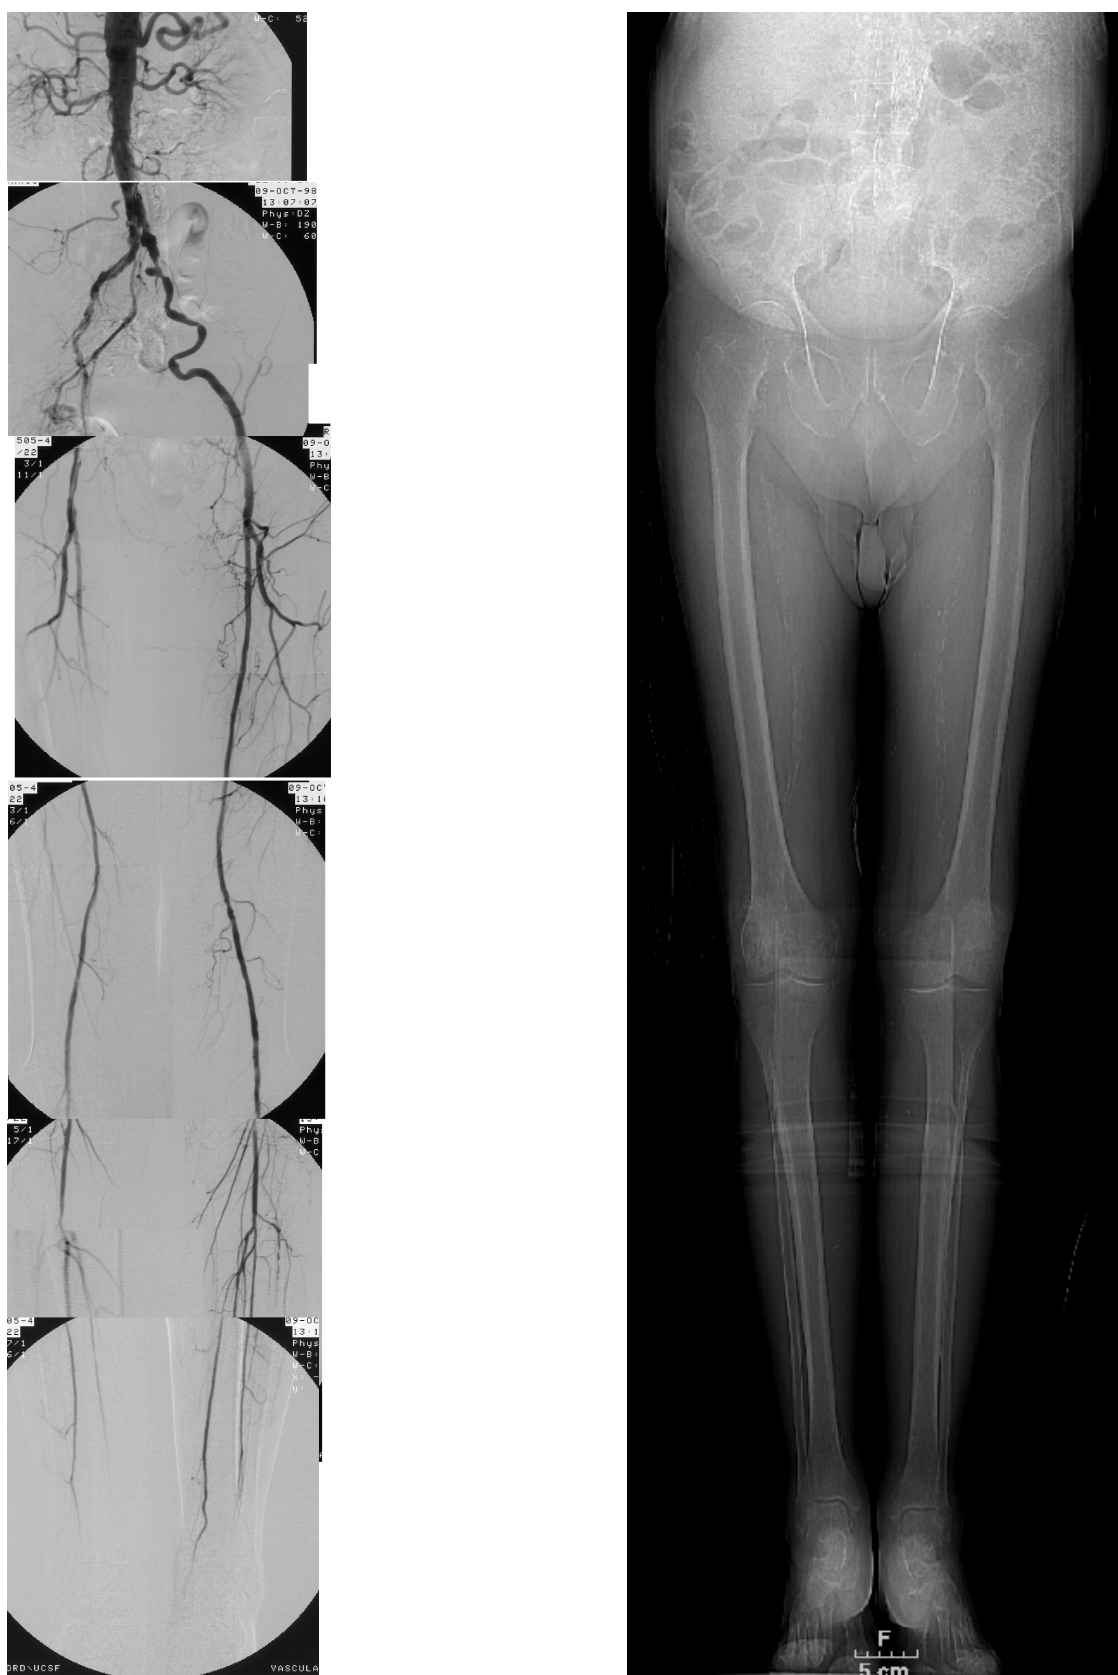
(a) Reconstructed full-size digital-subtraction angiogram (DSA) of a patient. (b) Standard 2D radiographic image of a patient without contrast medium, thus the vessels are not visible. Used e.g. for pre-scan alignment of a patient position in CTA.
